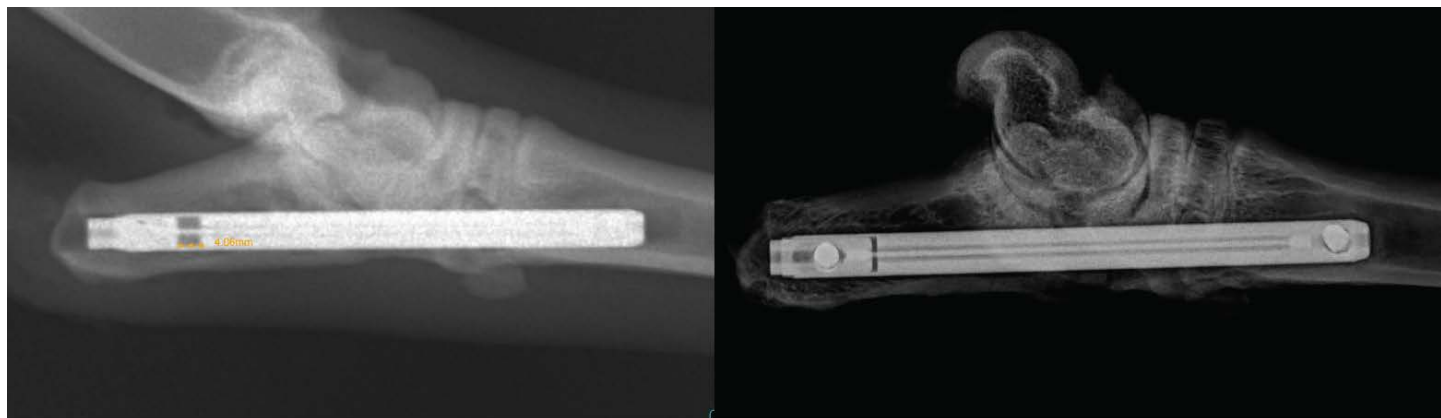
(left) Radiograph at post-op. (right) Radiograph after 4 months.
